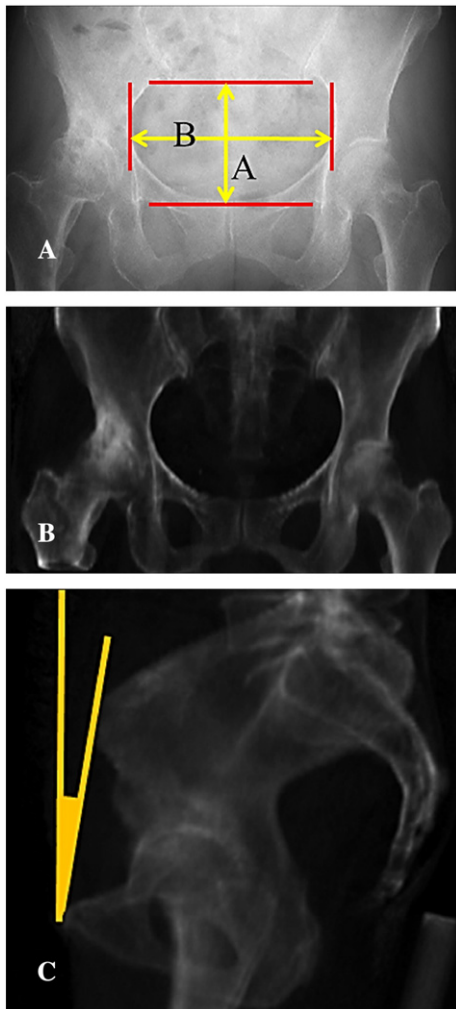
Measurement of PSI in a standing position. (A) On AP radiographs of the pelvis in a standing position, vertical diameter of the pelvic foramen (A) divided by horizontal diameter of the pelvic foramen (B) was calculated as VH ratio. (B) The pelvis was rotated sagittally until VH ratio of the pelvic foramen on DRR became similar to that of standing AP radiographs. (C) On sagittal DRR, the angle between APP and the vertical axis was measured as PSI in a standing position.
